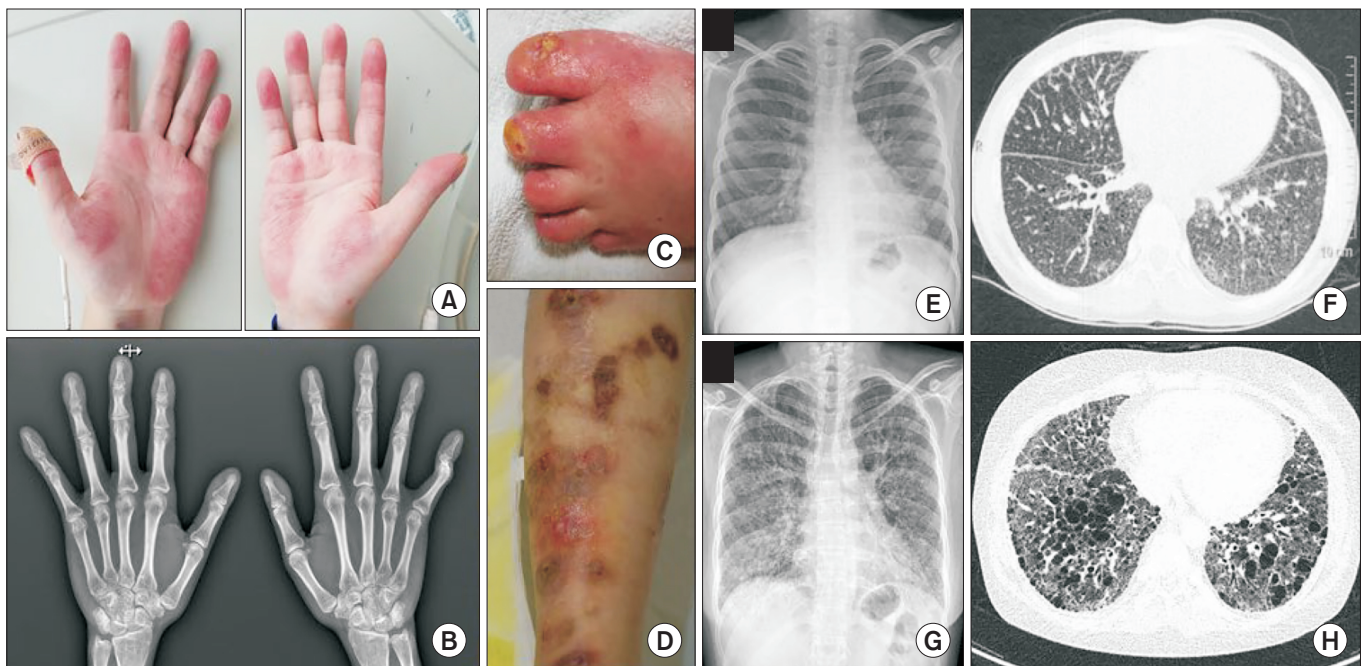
The phenotypes associated with stimulator of interferon gene-associated vasculopathy with onset in infancy (SAVI). (A) Joint contracture of finger, (B) hand both x-ray, (C) partial amputation of toes, (D) ulcerative lesions of calf, (E,F) chest radiograph and computed tomographic scan taken at 15 years of age, and (G,H) chest radiograph and computed tomographic scan taken at 30 years of age.
